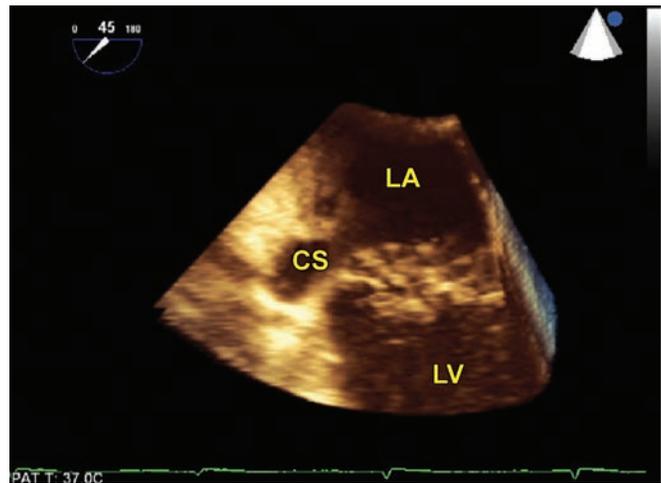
A cropped three-dimensional transesophageal four chamber view showing the opening of the coronary sinus fistula into the left atrium. (CS: Coronary sinus; LA: Left atrium; LV: Left ventricle).
